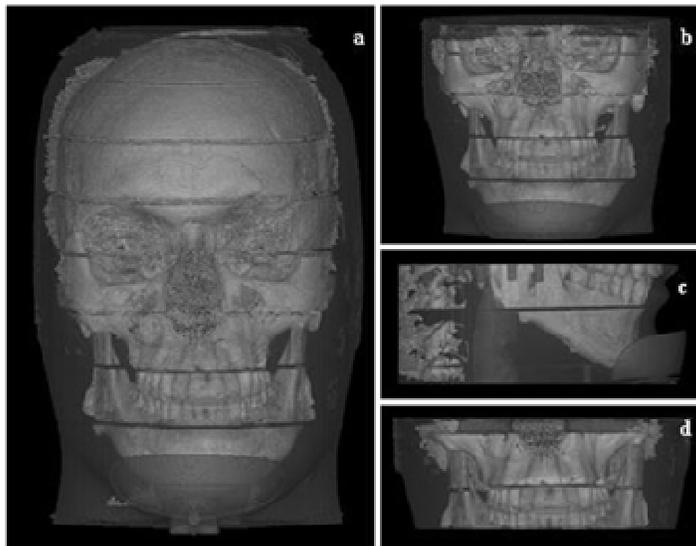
Typical FOVs in dCBCT: (a) full skull; (b) view of the two jawbones over 13 cm in height; (c) lower jawbone over 6 cm in height; (d) upper jawbone over 6 cm in height (from Roberts et al., 2009).
